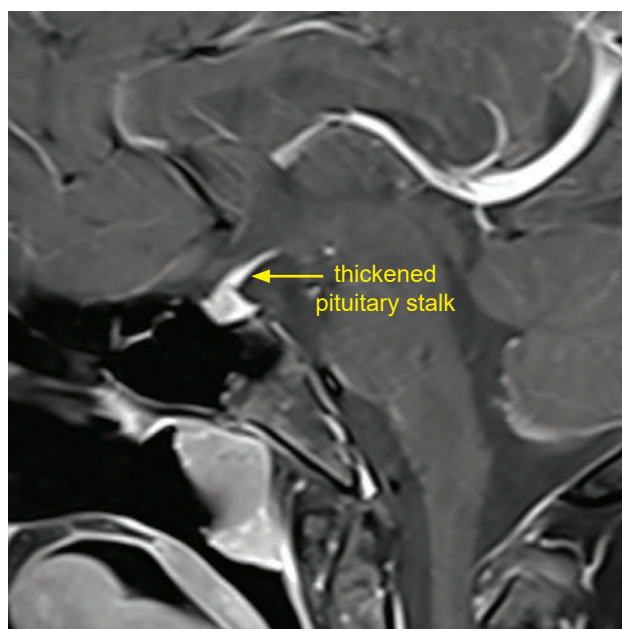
Post gadolinium sagittal (T1WI) MRI of pituitary showing homogenous enhancement of the pituitary stalk (yellow arrow). The pituitary gland is small in size and has no focal lesion.
